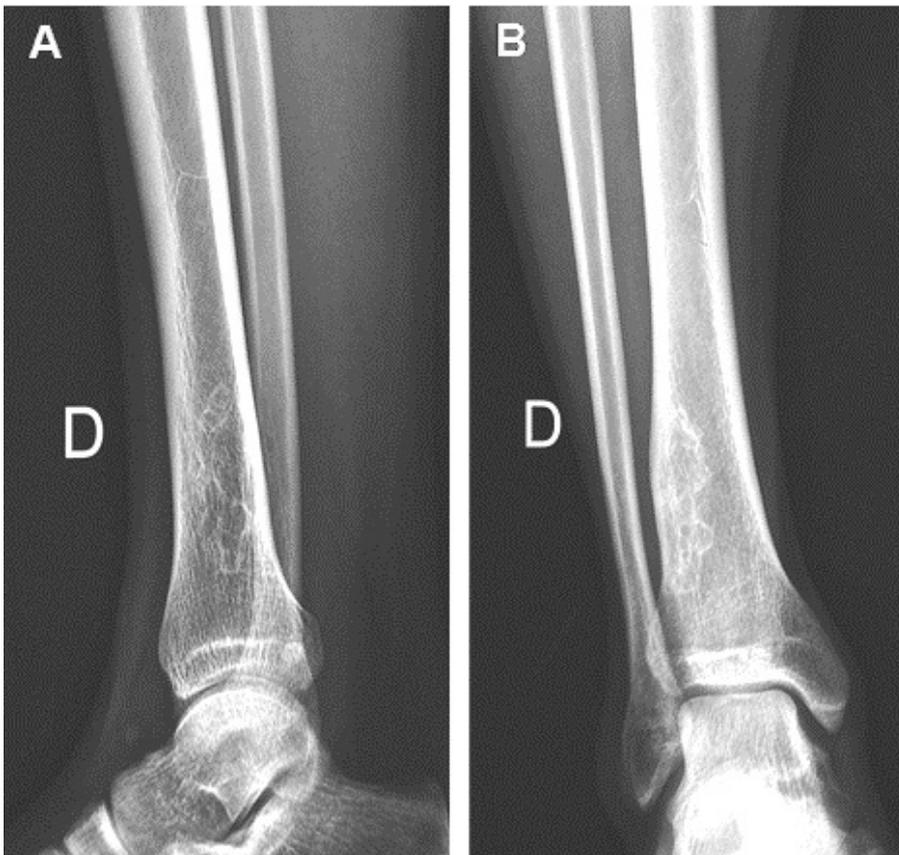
A and B - Lateral and anteroposterior X-rays of the ankle taken 3 year after the previous study. Compared to the previous images, the lesion shows greater density and filling and the bowing is less marked. The image is compatible with ossifying fibroma undergoing ossification.
